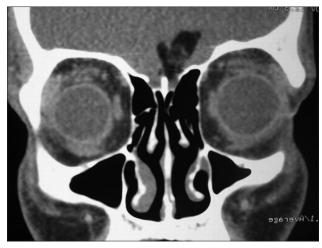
CT scan showing a hypodense lesion
